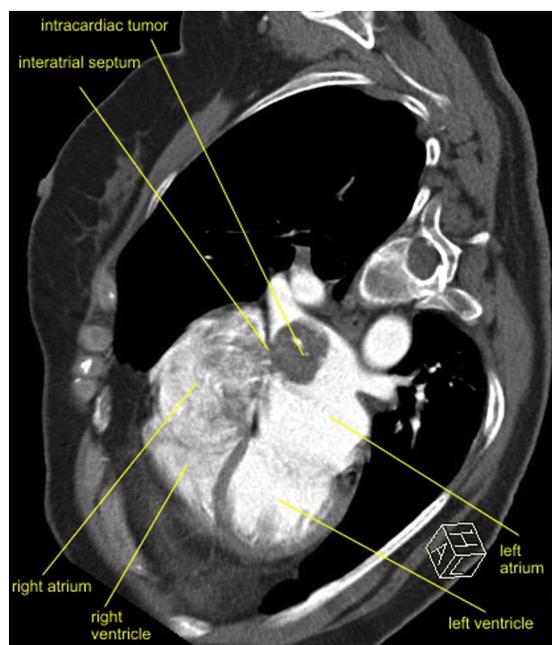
CT image after intravenous contrast administration, Multiplanar Reconstruction (MPR) through the tumor mass, visible attachment to interatrial septum.
